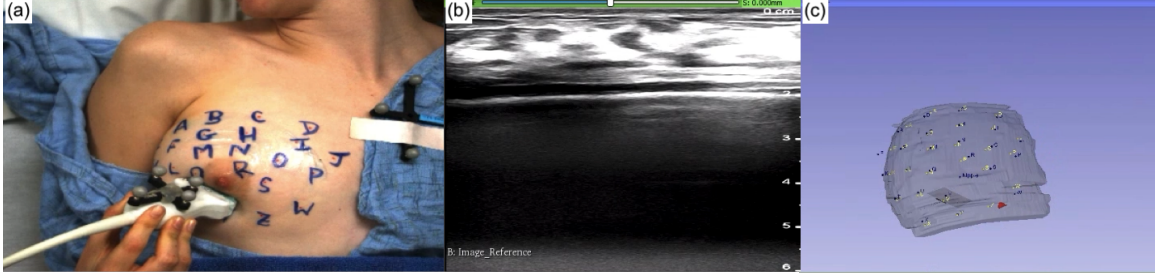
Tracked ultrasound allows for visualizing the image plane in 3D space. (a) camera view (b) ultrasound image, streamed into the integrated Slicer system (c) the 3D model view showing a semi-transparent rendering of the tracked ultrasound image plane in relation to a model of the breast, fiducial locations (blue and yellow), and a red mock tumor position.
